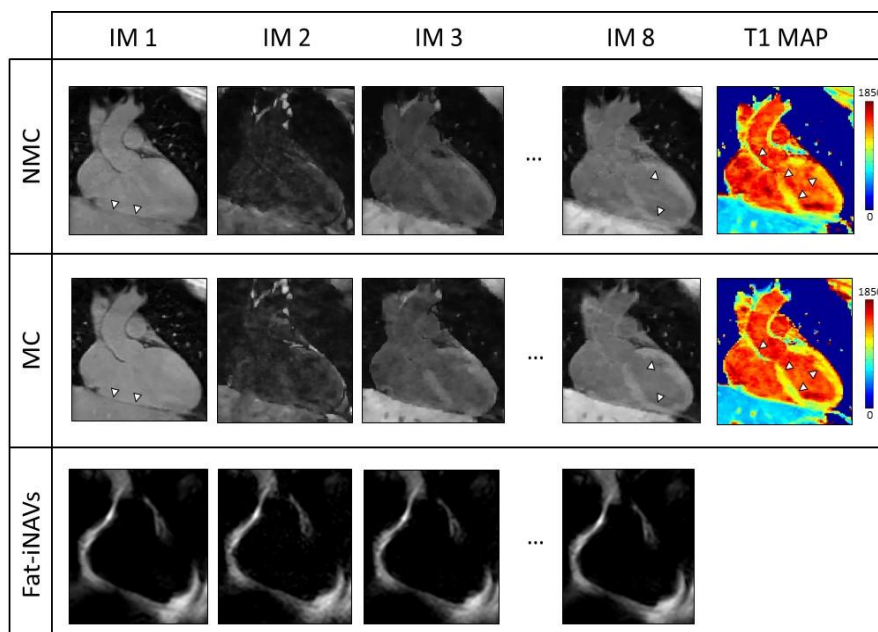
T1-weighted images and myocardial T1 map non-motion corrected (NMC) and motion corrected (MC) for one representative subject. In the bottom row the fat-iNAVs of the corresponding T1-weighted images are shown.
